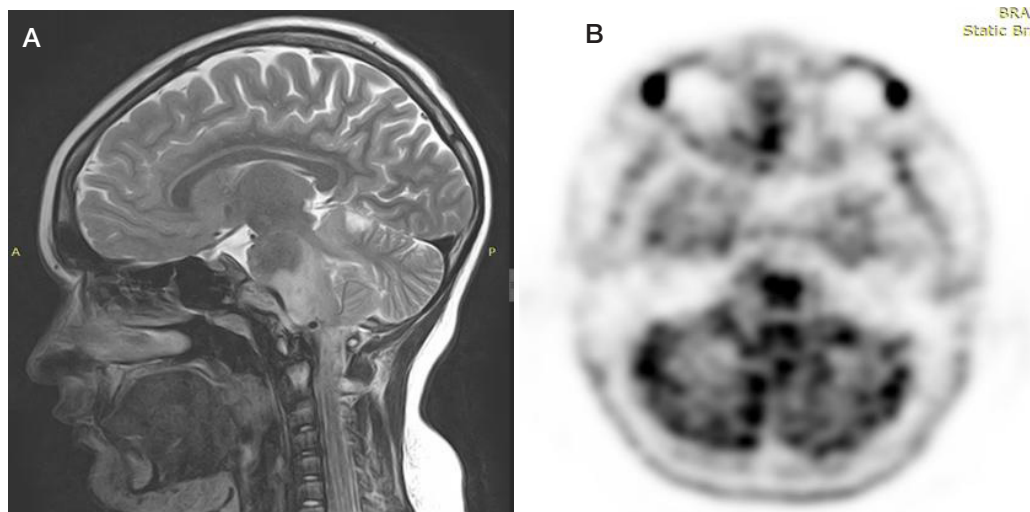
A. Sagittal brain MRI image (December 8, 2020). B. Axial 11C-methionine PET/CT image (January 11, 2021)
